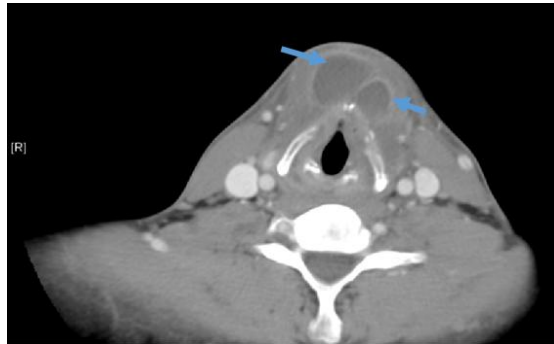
Repeat CT neck soft tissue showed minimal interval enlargement of neck abscess [Arrows]
